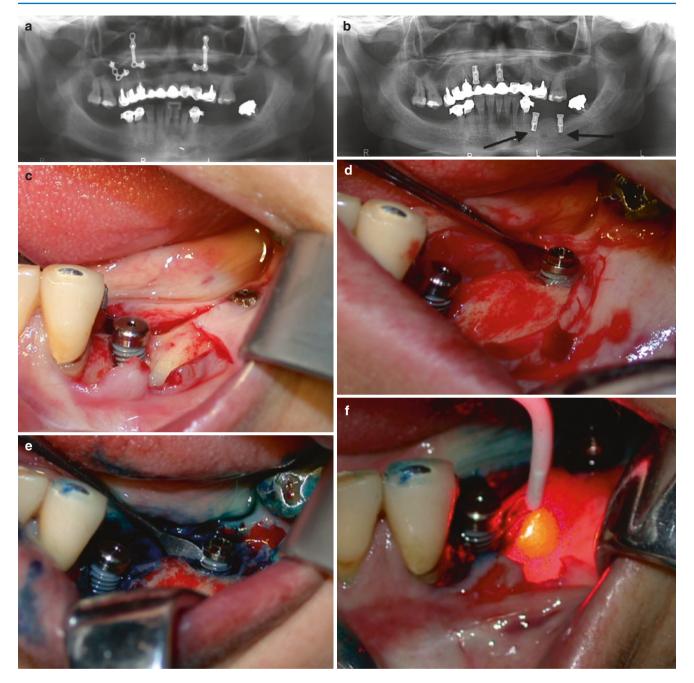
Peri-implantitis treatment. (a) Postoperative radiography of the patient subjected to LeFort I osteotomy to treat retromaxillism because of trauma. Mini-plates and screws are present in the maxilla. Chronic periodontitis involves majority of her teeth. The plan was to replace failing teeth with dental implants. (b) Four implants are inserted, and of those, two implants in the lower jaw (arrows) exhibit periimplantitis, 3 months after placement. (c) The mesial implant is uncovered first, showing the resorption of the buccal bone plate and exposed threads. (d) The distal implant is uncovered demonstrating exposed threads supracrestally. (e) The photodynamic therapy (the dye is applied) is applied after meticulous curettage has been carried out. (f) After the wound has been irrigated, the laser is applied to bring photons to the dyed areas. (g) ABP and the DBBM are applied. (h) GBR is completed using the CM. (i) Condition 6 months after treatment of periimplantitis. Bone conditions are improved and prosthetic rehabilitation carried out. (j) Intraoral view, showing only small portion of marginal gingiva of the lower bridge cemented to the treated implants. The photo
